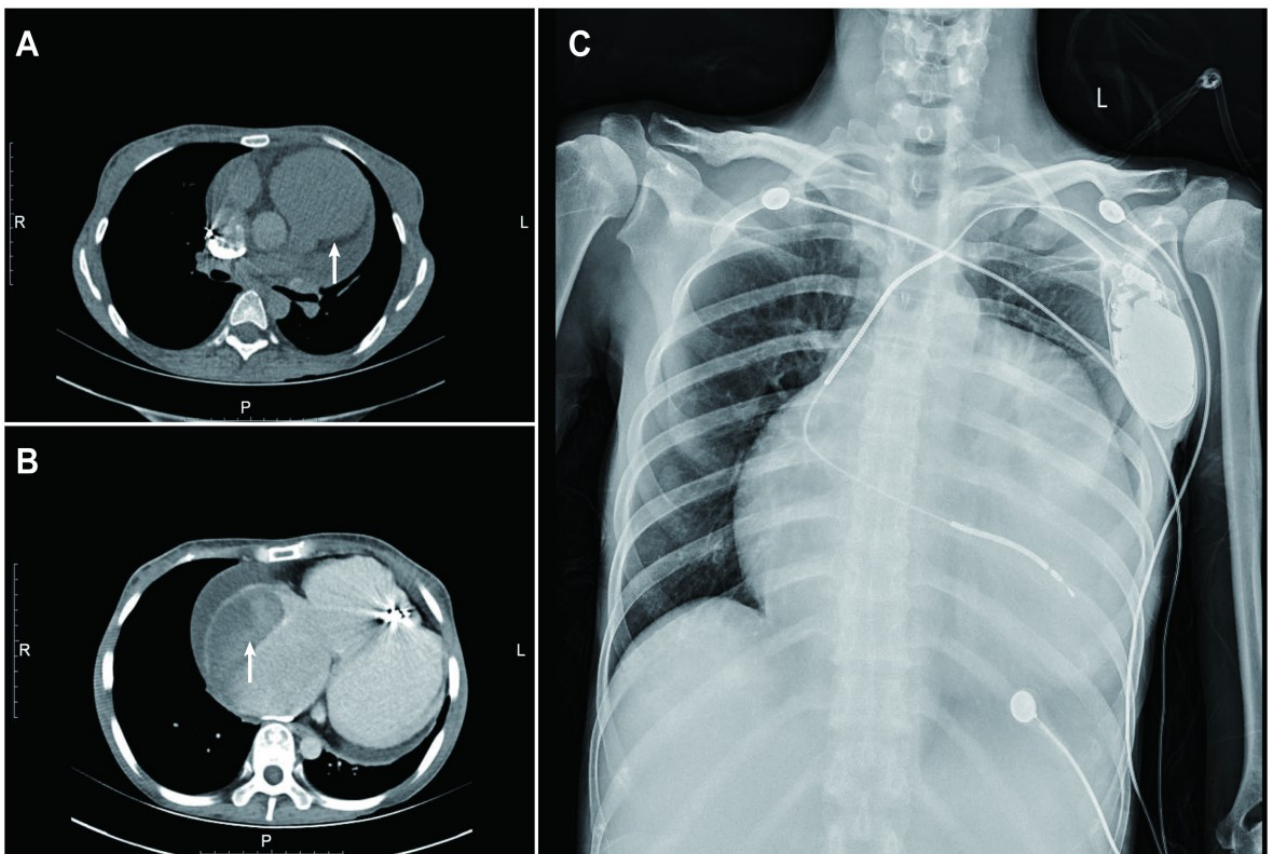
Computed tomography (CT) and X-ray manifestations. (A) A CT revealed an enlarged right ventricular outflow tract (white arrow). (B) CT showed a right atrium thrombus (white arrow). (C) X-ray showed cardiomegaly. R stands for right, L for left, and P for posterior.
